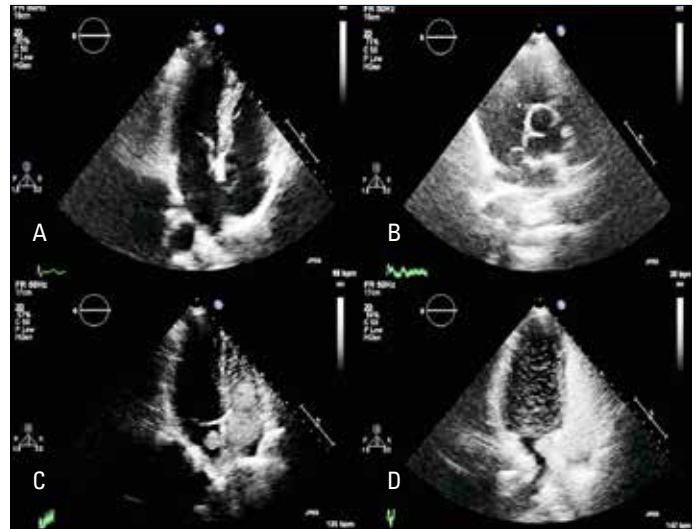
A, B) TTE apical 4-chamber and subcostal views of a giant, mobile IASA, C, D) Apical 4-chamber view spontaneous and during Valsalva maneuver bubble transition from right-to-left atrium
